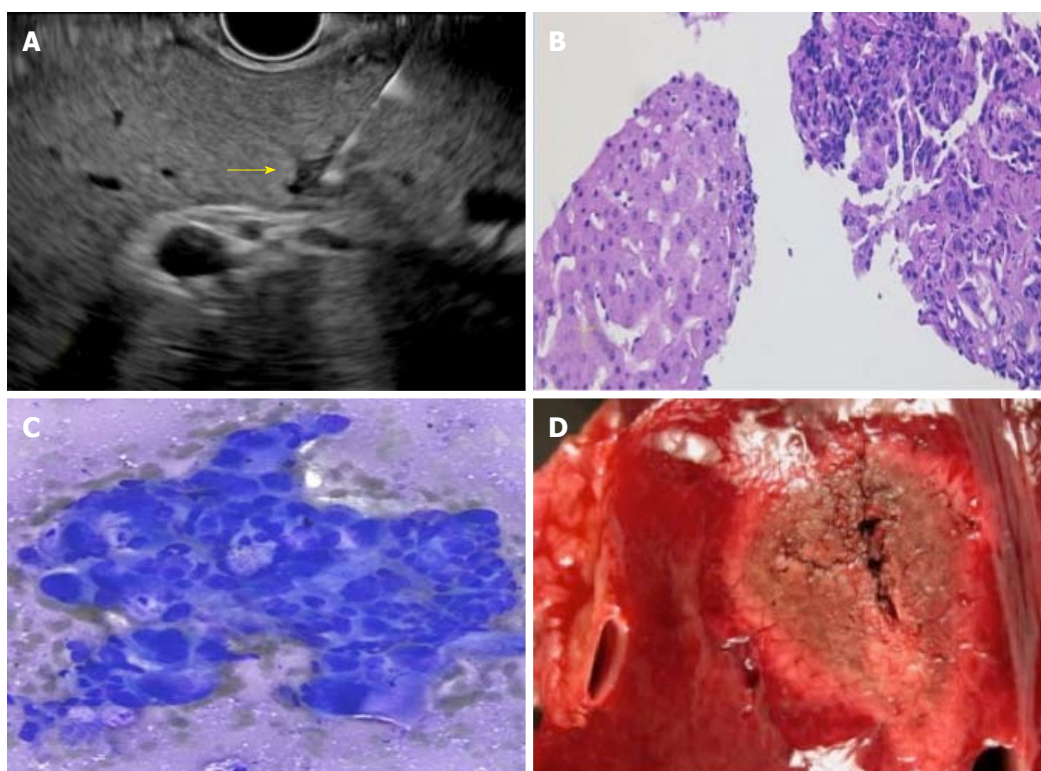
Endoscopic ultrasonography diagnosis of secondary liver lesions. A: Fine needle aspiration performed on small hypoechoic lesion in the liver; B and C: Pathology suggested pancreatic metastatic lesion; D: Partial hepatectomy performed for a solitary metastatic lesion.
